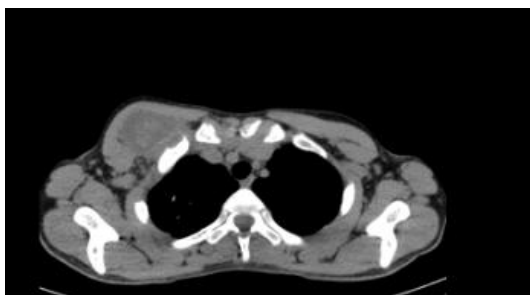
CT image showing swelling in right anterior chest wall
